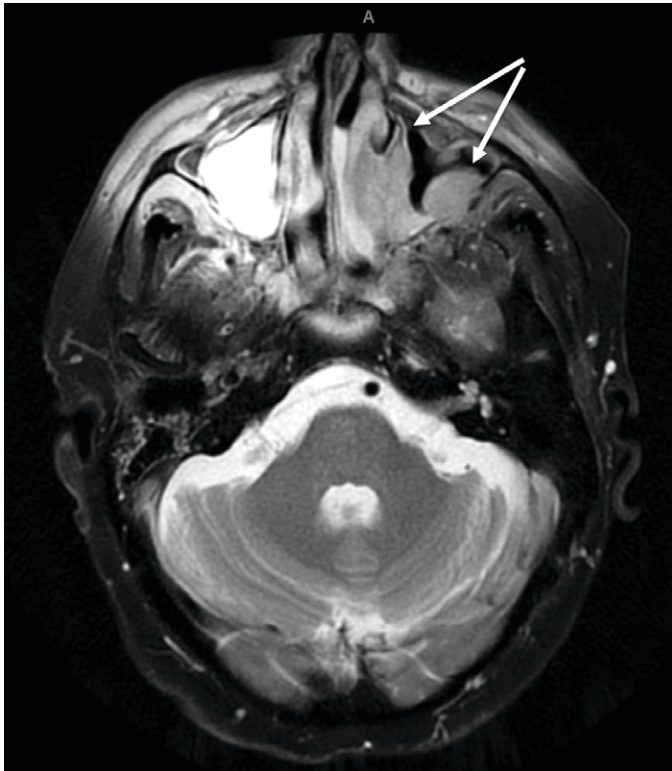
An MRI of the brain and sinuses in T2/FLAIR sequence showing abnormal soft tissue within the superior/medial aspect of the left orbit, which appears to be contiguous with abnormal soft tissue filling the left frontal, ethmoid, and maxillary sinuses (white arrows). A small amount of mass effect is on the left medial rectus muscle.
